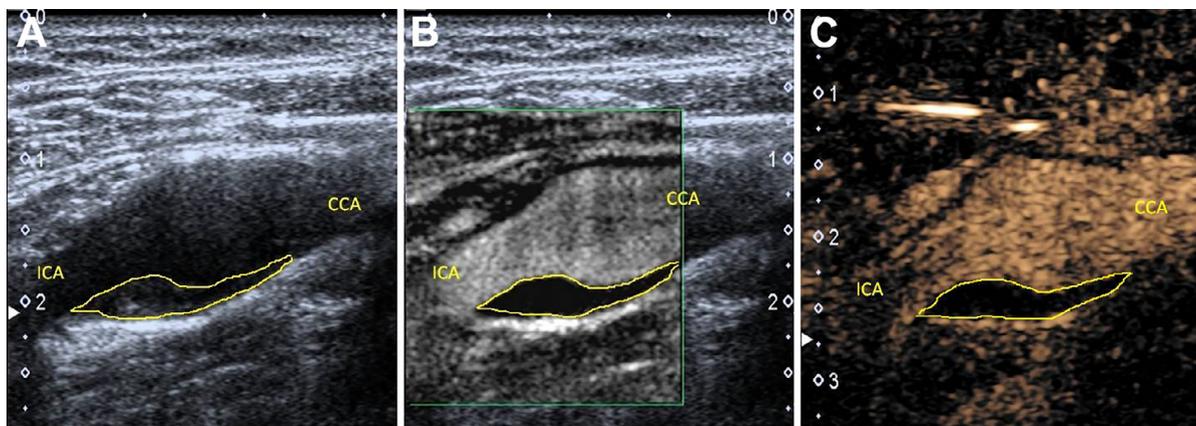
Grayscale ultrasound, SMI, and CEUS images in the same 67-year old male patient at T1. (A) Grayscale ultrasound sagittal image. (B) SMI sagittal image. (C) CEUS sagittal image. Abbreviations: CEUS, contrast-enhanced ultrasonography; SMI, superb microvascular imaging; T1, 6-month after atorvastatin treatment. (Color version of figure is available online.)
